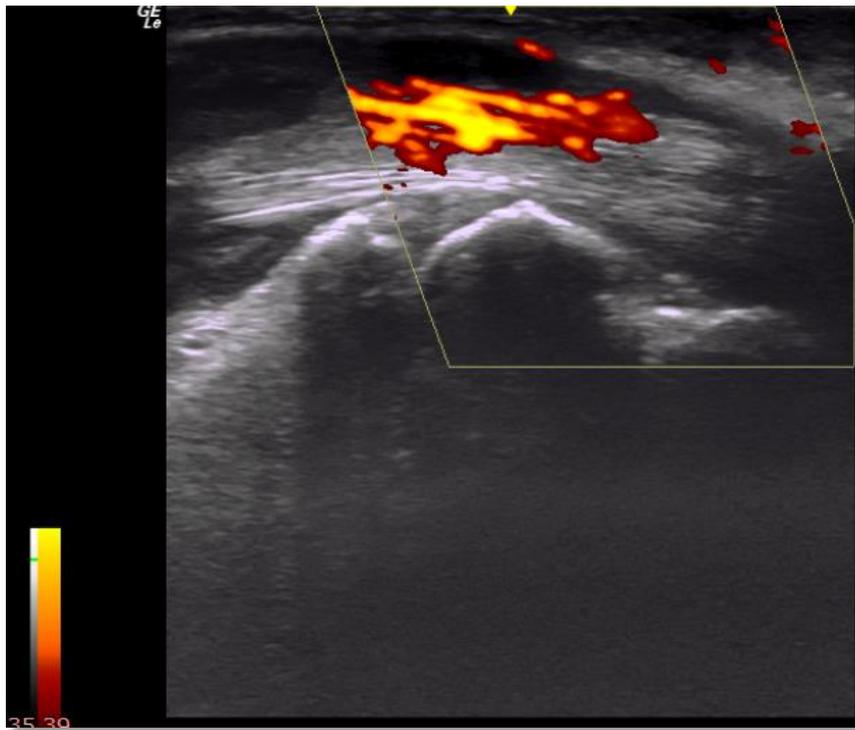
Wrist, palmar midline sagittal, showing flexor digitorum superficialis power Doppler activity over the distal end of the radius, lunate and capitate in active rheumatoid arthritis patient.
